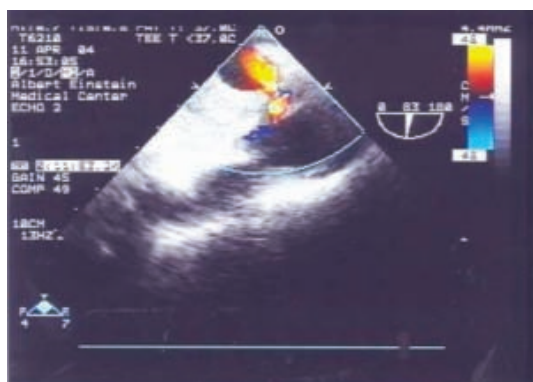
Transesophageal echocardiogram showing a penetrating atherosclerotic ulcer in a patient with aortic dissection.
